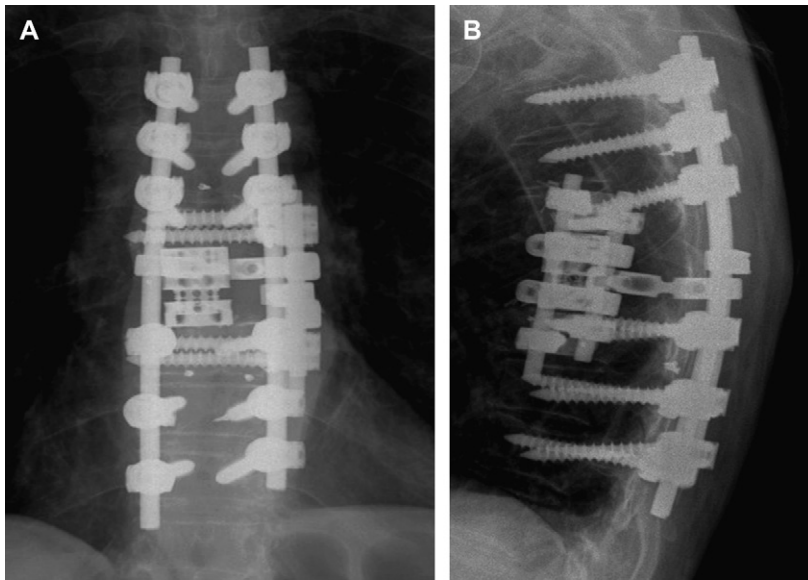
Anteroposterior (*A*) and lateral (*B*) radiographs after T8 corpectomy with implant of an expandable interbody cage, T7–T9 lateral fusion plate, and T5–T11 pedicle screws and rods. This patient’s initial surgery (without preoperative embolization) was limited by excessive blood loss to a decompressive laminectomy. Extensive posterior fixation was performed to prevent progression of a marked preoperative kyphotic deformity in this patient.
